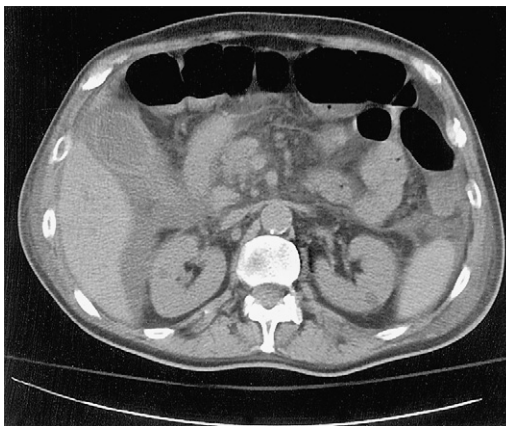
CT of the abdomen showing AAC. Note the thickened, contrast-enhanced wall of the gallbladder, ventral to the right hepatic lobe, and the large amount of surrounding ascites (pericholecystic fluid). No gallstones were visualized.
